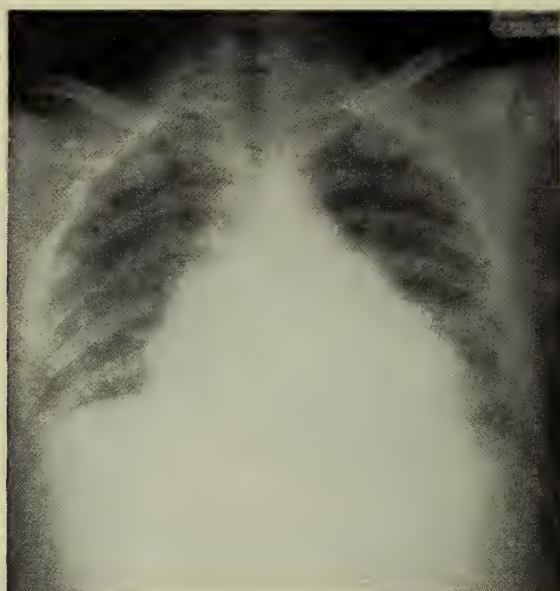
(Case 1) Portable chest X-ray on the 28th hospital day showing marked enlargement of the cardiac silhouette.
